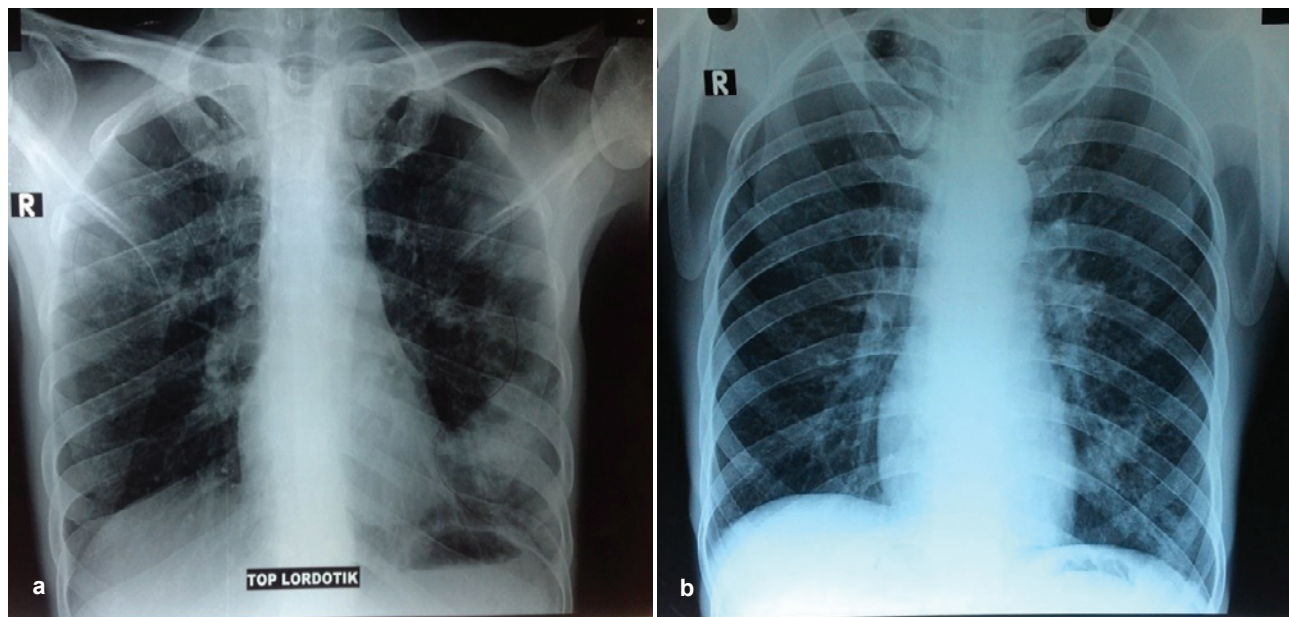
Chest radiographs (a) apicolordotic view revealed fibrotic infiltrates and calcifications on the upper right and lower left lung fields. (b) improvement after 2 weeks of antituberculosis treatment.
